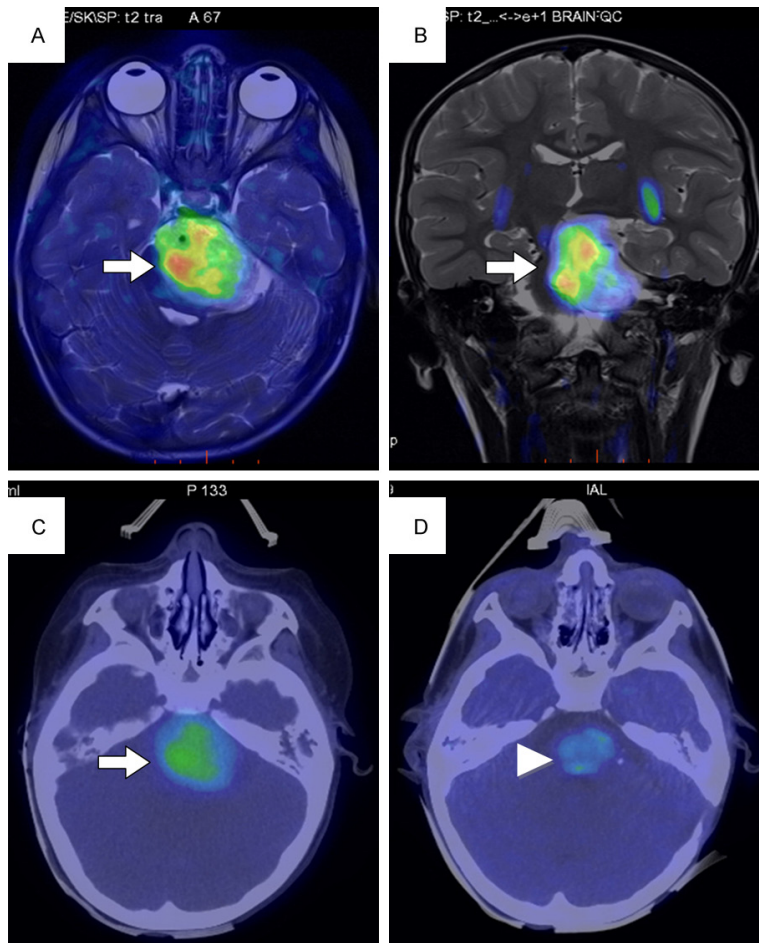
[^{18}F] DOPA therapy monitoring in 4-year-old patient with Neuroendocrine embryonal tumor with multilayered rosettes (ETMR). Axial (A) and coronal (B) MRI-PET fusion images and axial PET/CT (C) images showing brainstem uptake (arrow); axial PET/CT (D) after systemic chemotherapy and proton therapy shows lower brainstem uptake (arrowhead).
